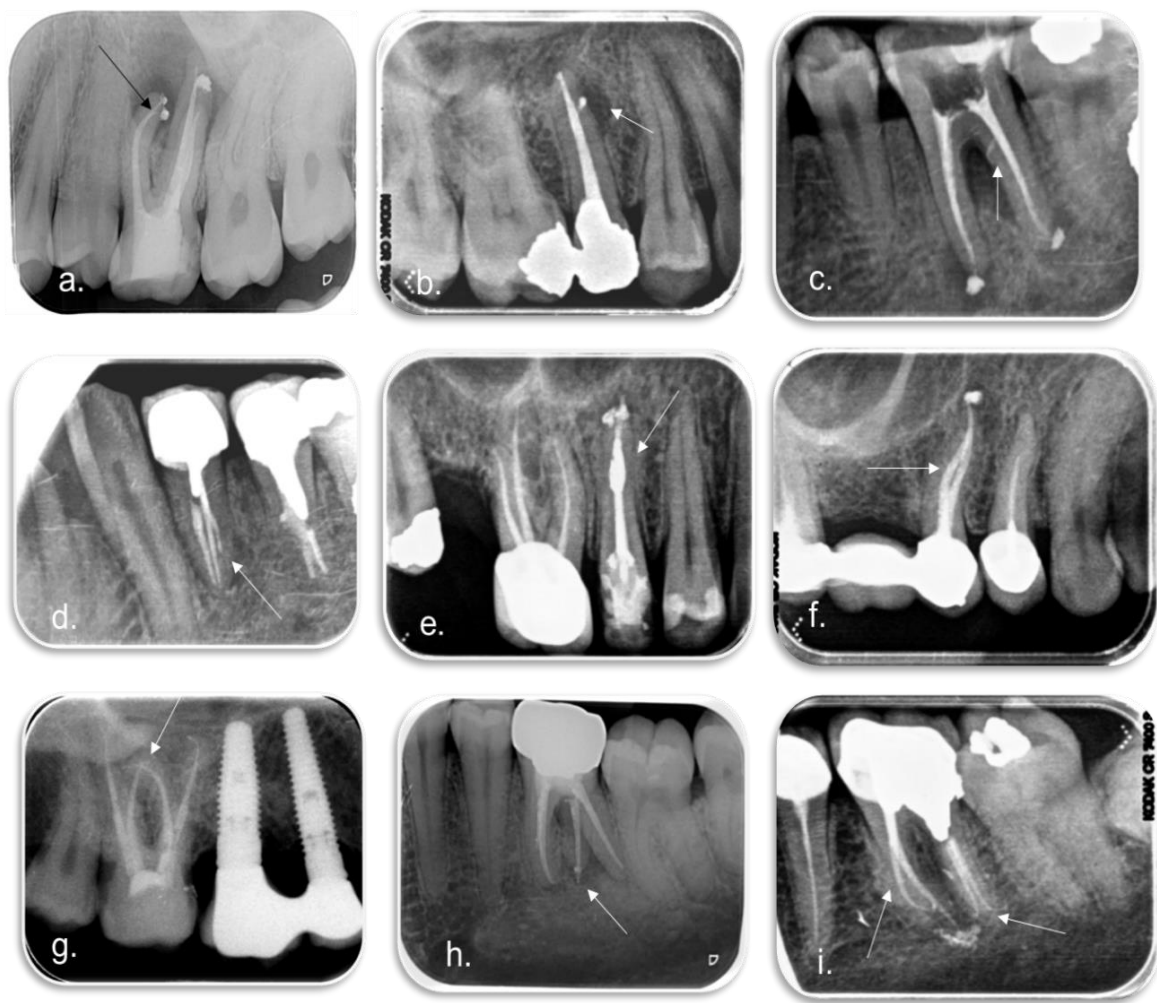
Periapical radiographs which present anatomical challenges of the root canal system (from KI personal archive). (a) Apical delta in an UL6; (b) Apical lateral canal in an UR5; (c) Coronal lateral canal and furcation involvement in a LL6; (d) Three separate canals in a LL4; (e) Internal root resorption in an UR5; (f) S-shaped root canals in an UR5; (g) Two independent palatal roots in an UR7; (h) radix entomolaris in a LL6; (i) Mesial and distal roots with a main root canal orifices dividing in two independent canals in middle root third.
